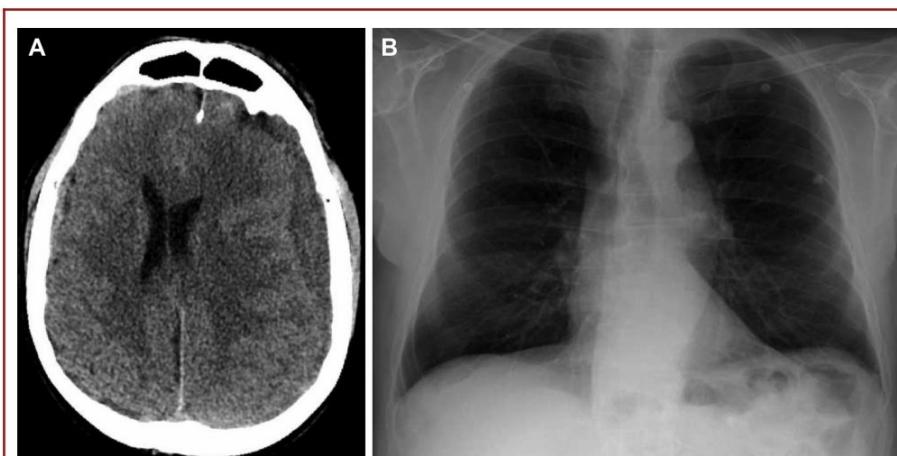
A. Head CT scan, axial view: left CSDH. B. normal CXR.
